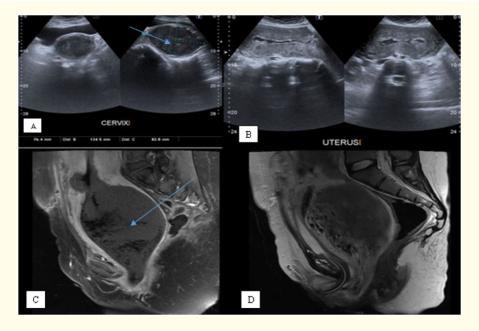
Case Five, US (A, B) shows postpartum bulky uterus with small amount of fluid within the endometrial cavity. Large hypo echoic mass without vascularity protruding into the vagina (arrow). MRI (C, D) shows postpartum bulky uterus, abnormal signal intensity lesion arising from anterior wall of the cervix and hanging into the upper half of the vagina. It is hypo intense on T2WI and shows no post contrast enhancement (arrow). The appearances represent a large degenerating sub mucosal fibroid with prolapse into the vagina.
